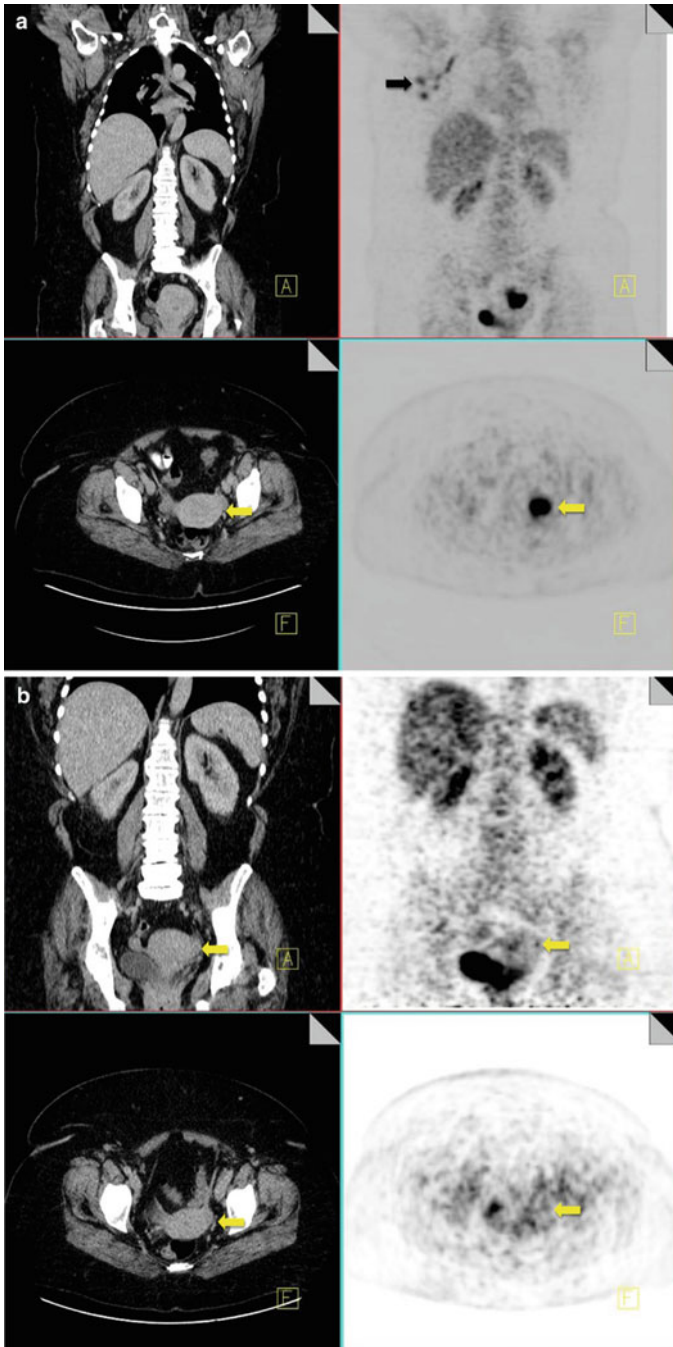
FDG PET/CT scan of patient with inflammatory breast cancer. Increased uptake observed within endometrial canal due to menstruation (*top* four images). Same patient when not menstruating (*bottom* four images) does not demonstrate any increase in uptake [18]
